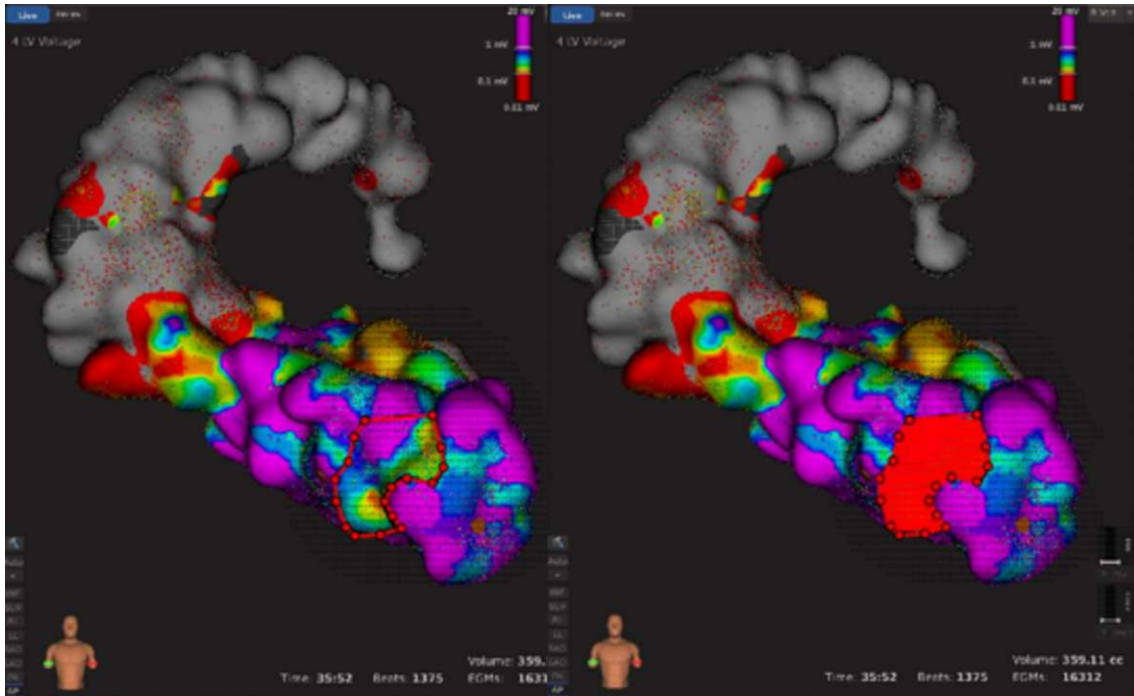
Generation of polygonal chain and 2D target area on the cardiac CT (Taken from the CARDIO-RT Software Instruction Manual, Institute for Robotics and Cognitive Systems, University of Lübeck, Lübeck, Germany, 2023).
